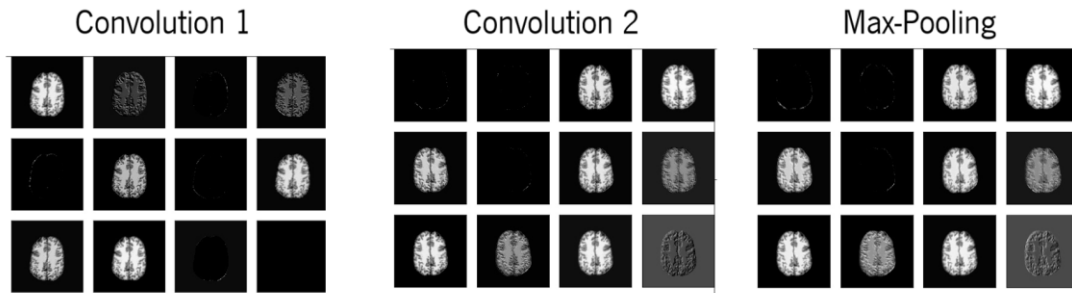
Example of final feature maps of the first convolutional and max pooling layers using human's MRI
